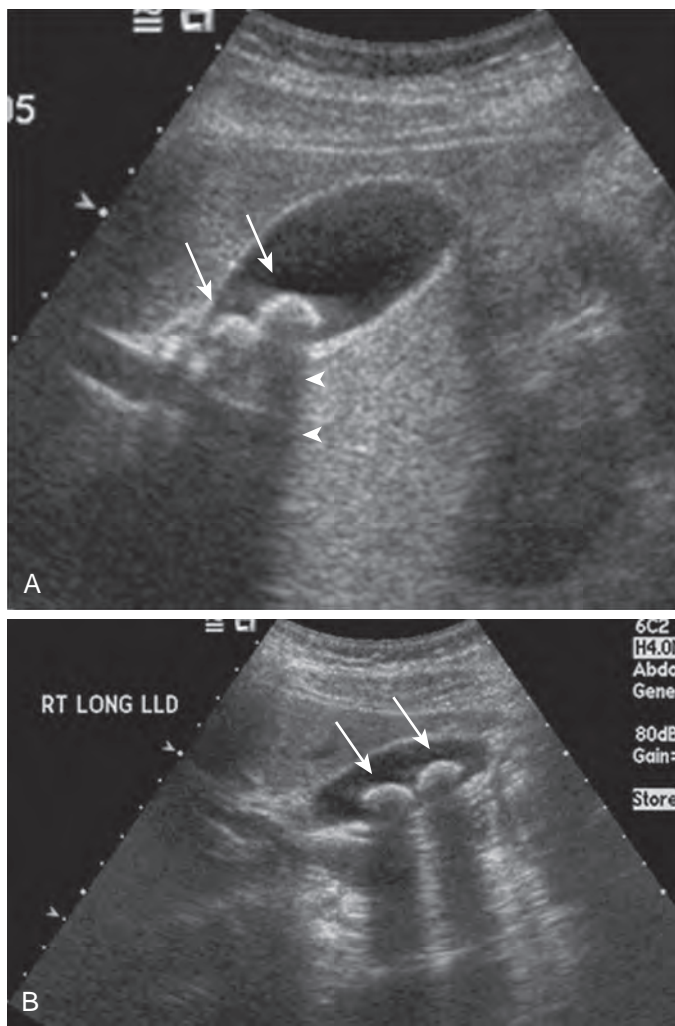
Gallstones: sonography. A. Two highly reflective echoes (arrows) are located in the dependent portion of the gallbladder lumen with posterior acoustic shadowing (arrowheads). B. When the patient is imaged in the left lateral decubitus position (LLD), the gallstones (arrows) change location, indicating mobility.
